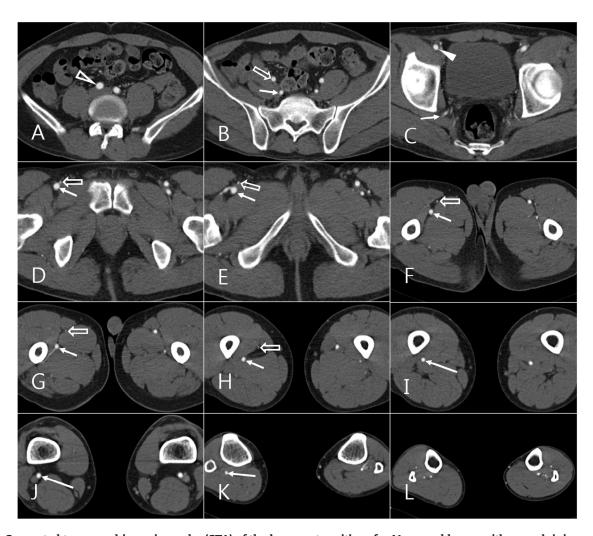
Computed tomographic angiography (CTA) of the lower extremities of a 41-year-old man with a crush injury of the left foot. (A, B) The axial CTA images of pelvis show the right common iliac artery (empty arrowhead) bifurcating into the external iliac artery (empty arrow) and the internal iliac artery (short arrow) with normal bifurcation type and pathway of the iliac vessels. (C-L) The axial CTA images of the lower extremities show the right common femoral artery (arrowhead) bifurcating into the hypoplastic superficial femoral artery (empty arrows) and the deep femoral artery (small arrows) connecting to the popliteal artery (long arrows) in the right lower extremity. The arterial system of the left lower extremity is normal.
